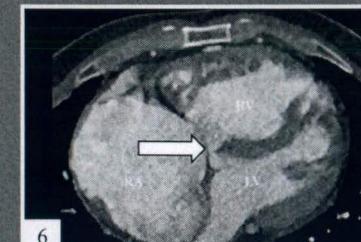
Cardiac CT more clearly demonstrating uncorrected membranous ventricular septal defect.
